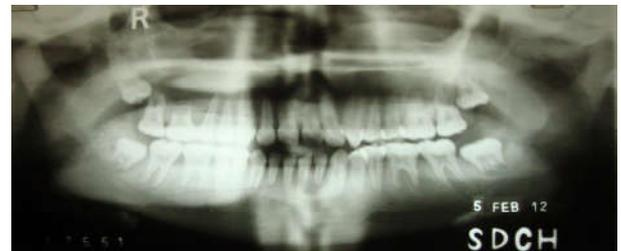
Post-operative Orthopantomogram after 1 year
